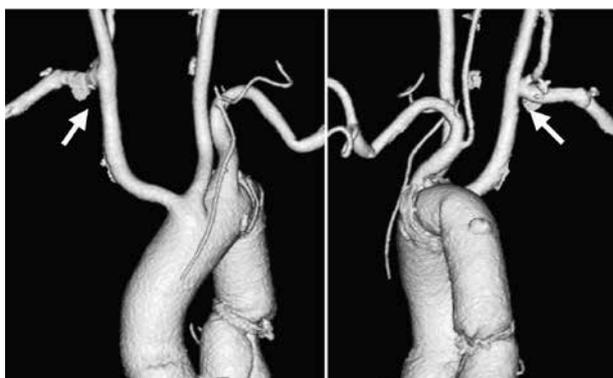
Postoperative three-dimensional CT image demonstrated that right aberrant subclavian artery was anastomosed right carotid artery (arrow) and descending aorta was replacement.
